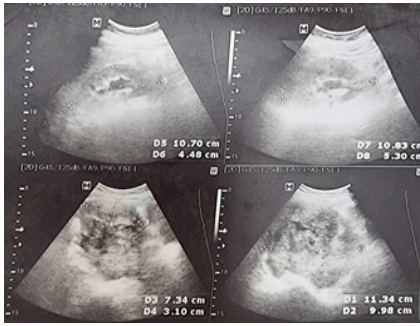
Ultrasound. A large solid lobulated mass with some cystic changes at the presacral area measuring 15.0 x 10.0 x 11.3 cm pushing the uterus anteriorly and superiorly
